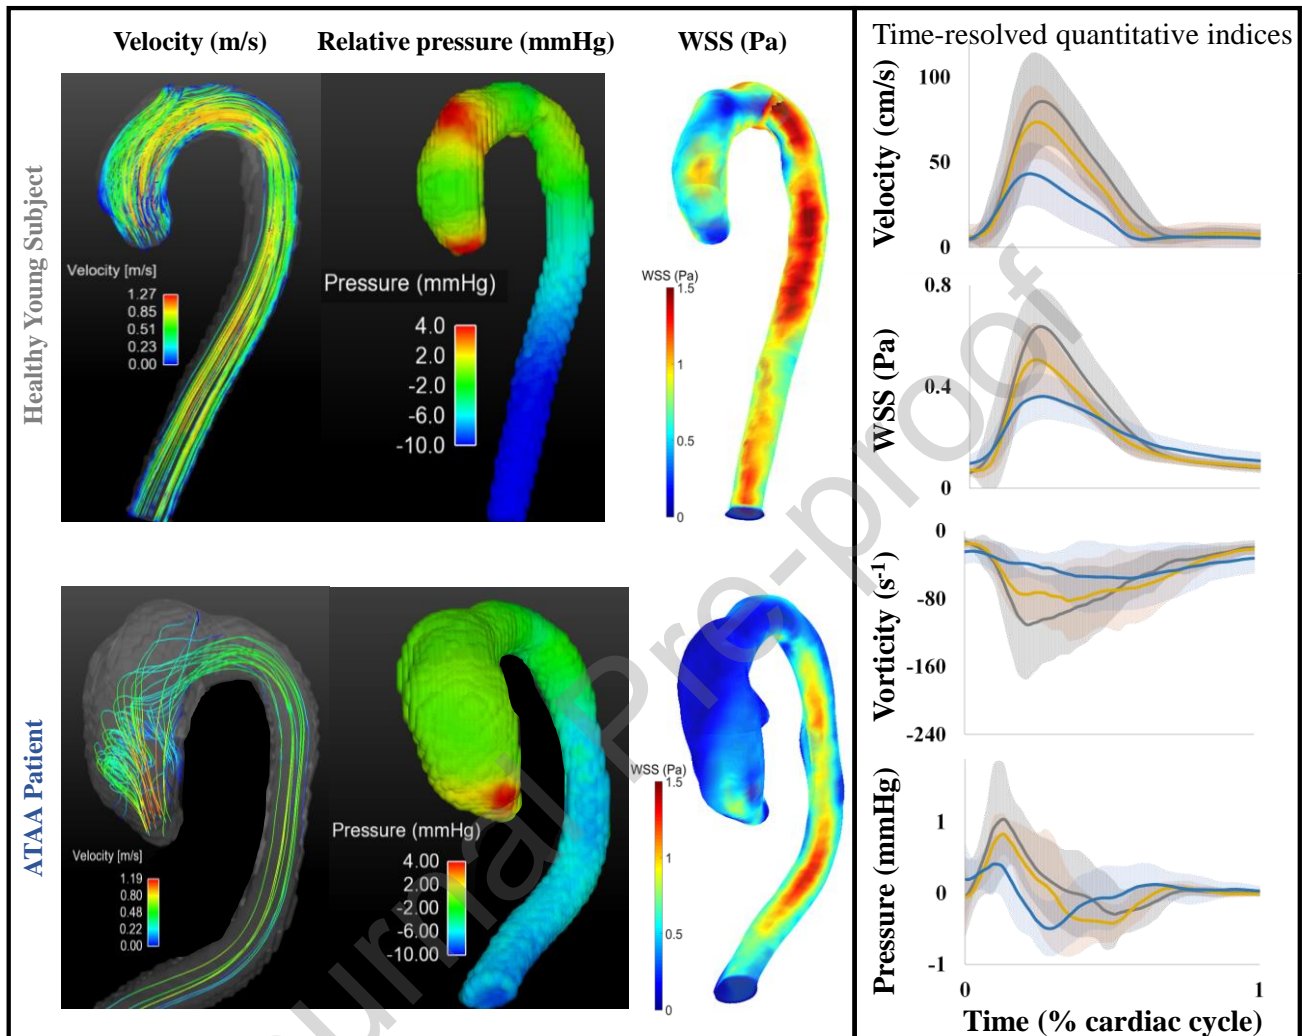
Aortic 4D flow MRI-derived velocity, relative pressure, WSS and vorticity. Examples of quantitative hemodynamic maps for a young healthy volunteer (top) and a patient with a dilated ascending aorta (bottom), along with mean (solid lines) and standard deviation (shades) for time-resolved velocity, WSS, vorticity and relative pressure curves in the ascending aorta of young healthy subjects (grey), elderly healthy subjects (yellow) and ATAA patients (blue). Time curves were rescaled between 0 and 1000 ms for all patients before averaging them and the averaged curve was then truncated at 700 ms.
